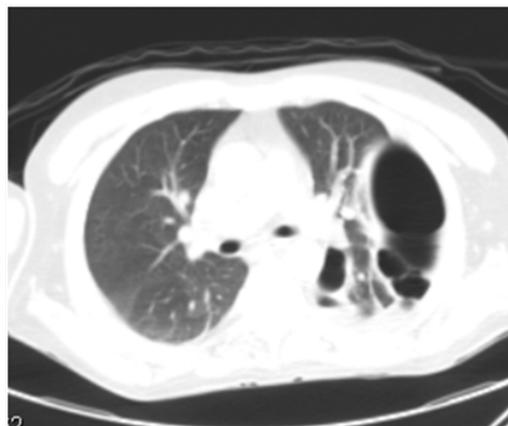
CT scan of this pneumothorax and other cysts.
